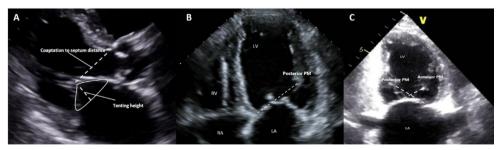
Examples of mitral valve geometry measurements on two-dimensional transthoracic echocardiography.
